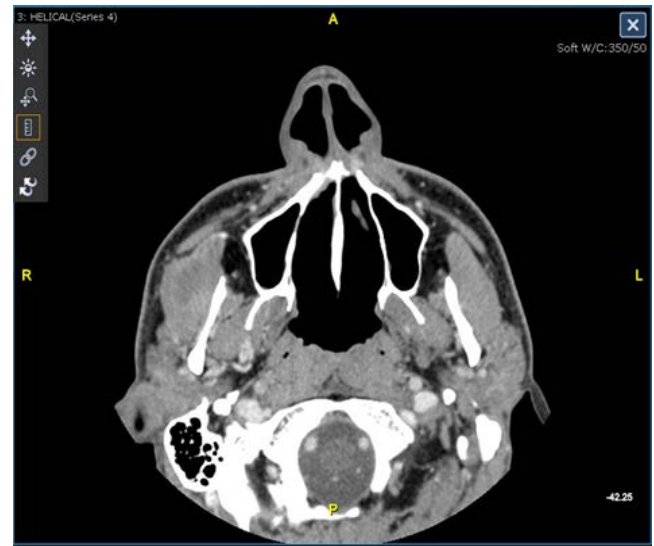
2 CT Maxillofacial with Contrast
